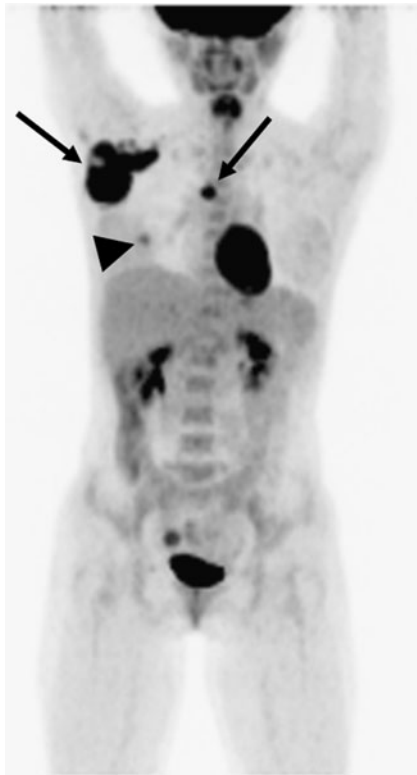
Maximum intensity projection image of ^{18}F -FDG PET/CT scan. A moderate focal ^{18}F -FDG uptake is seen in the right breast (arrowhead) with multiple intense ^{18}F -FDG uptake in the right axilla and mediastinum (arrow)
